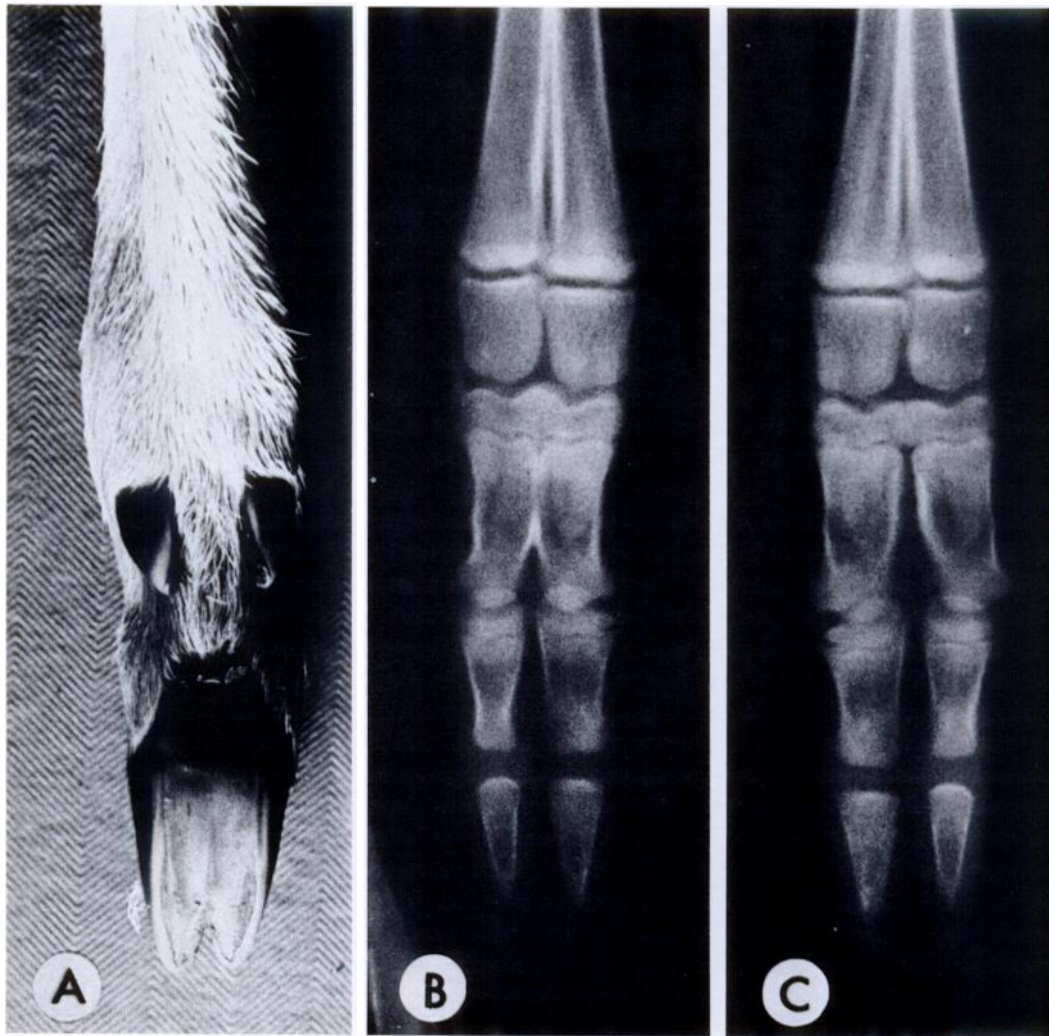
Syndactylous front feet of a female white-tailed deer fawn. A) Palmar view of right foot. B) Dorsopalmar radiograph of right foot. C) Dorsopalmar radiograph of left foot.
